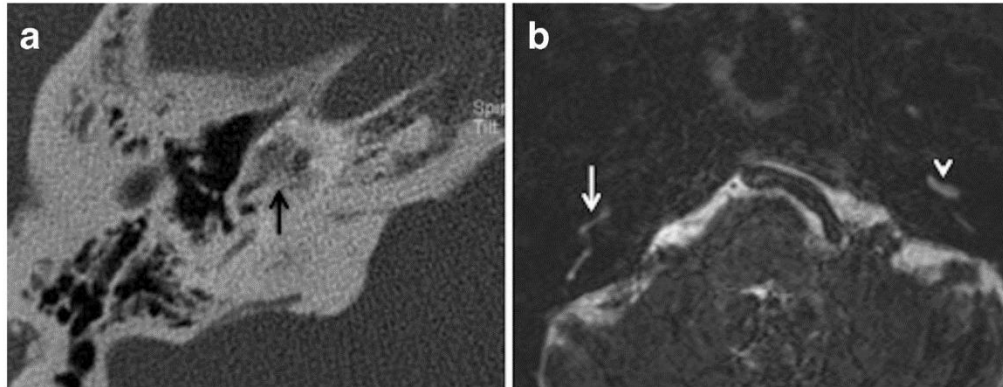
a Axial HRCT of the right temporal bone in a patient with known bilateral cochlear otosclerosis. There is almost complete obliteration of the basal turn of the right cochlea (*arrow*) by the otosclerotic process. b Axial MRI of the temporal bones in the same patient as (17a) at the level
